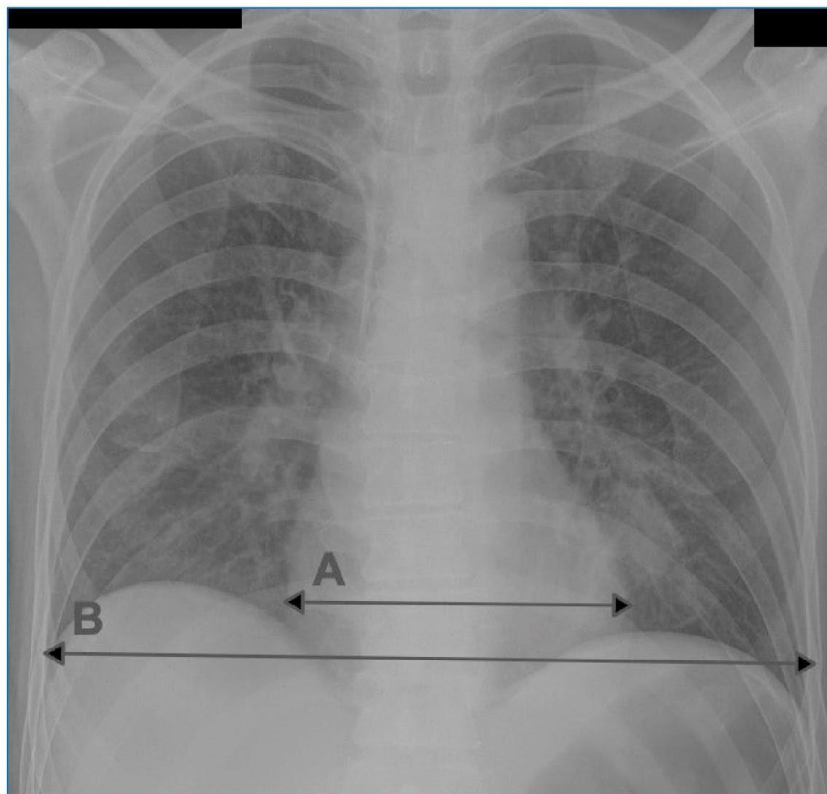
An example of CTR measurement on a chest radiograph in the AP projection. A: transverse dimension of the heart silhouette, B: transverse dimension of the chest.
